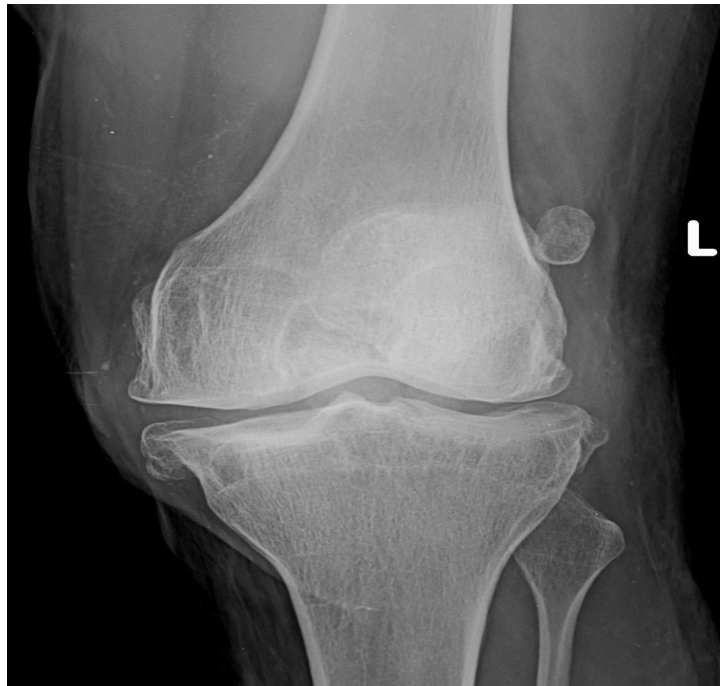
X-ray of knee joint showing OA changes
